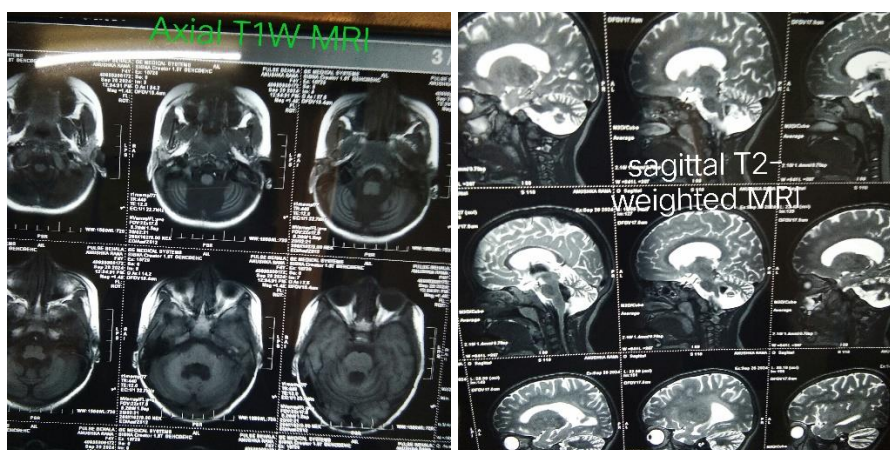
MRI brain images
